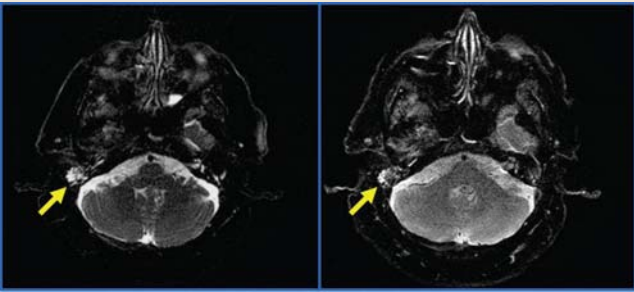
Example of a research study being conducted at 1.5T: High Resolution Structural and Quantitative MRI in Cholesteatoma (see arrows). This collaboration is between Samantha Holdsworth, PhD (Lucas Center, Radiology), Nancy Fischbein, MD (Radiology) and Nikolas Blevins, MD (Otolaryngology). Research sequence “rs-epi” (right) displays increased spatial resolution and reduced echo time versus that of a product propeller sequence (left).
